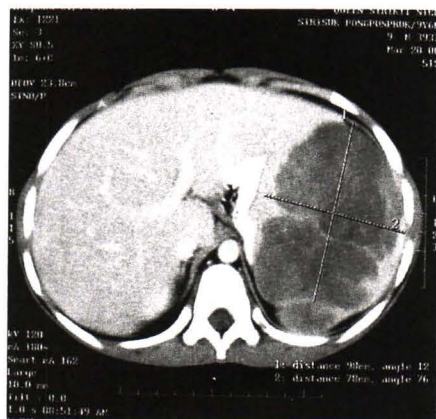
A large soft tissue mass in the left upper quadrant from the abdominal CT scan.
